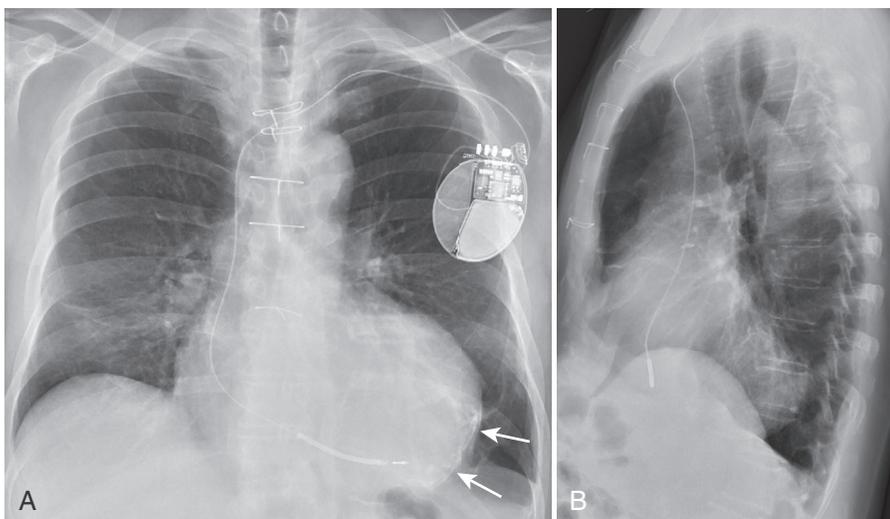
PA (A) and lateral (B) chest radiographs in a patient with a calcified left ventricular pseudoaneurysm (*arrows*). The lateral view reveals posterior extension of the pseudoaneurysm.
